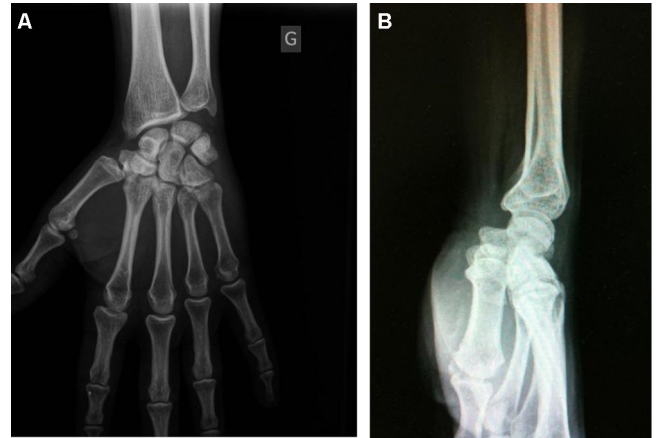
A/P (A) and lateral (B) radiographs of the wrist.
